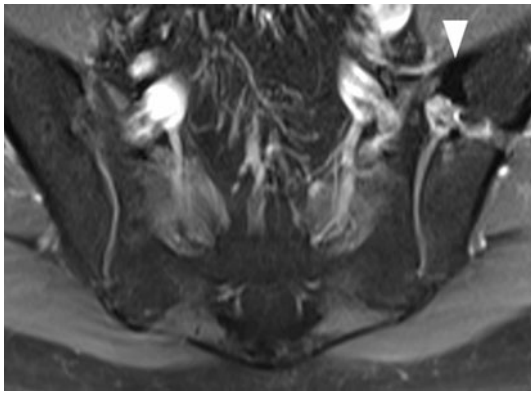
Follow-up axial gadolinium-enhanced fat-suppressed T1-weighted (TR/TE = 425/9) turbo spin echo MR image of the pelvis shows fusion (*arrowhead*) of the anterior portion of left SI joint. Minimal residual bone marrow edema is noted in the sacral aspect of the SI joint. The drilled left iliac bone canal is still visible
